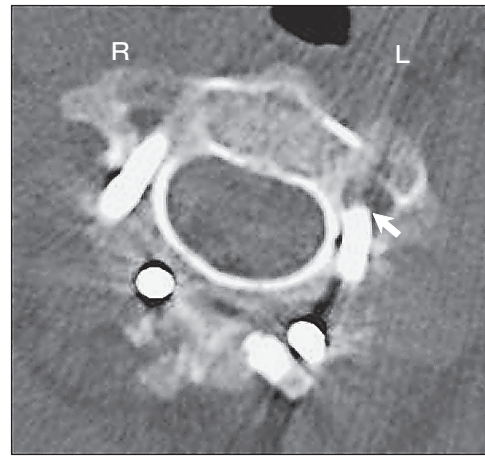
Postoperative CT. The white arrow shows screw misplacement on the left side.
